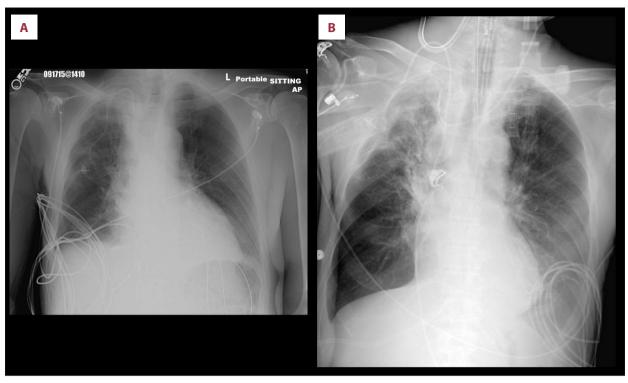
Portable chest radiograph on admission (A) showing cardiac silhouette within normal limits for a portable exam. Portable chest radiograph after pericardiocentesis and 3 liters of IV fluids given during the resuscitation of septic shock (B), showing more obvious pulmonary infiltrates.
